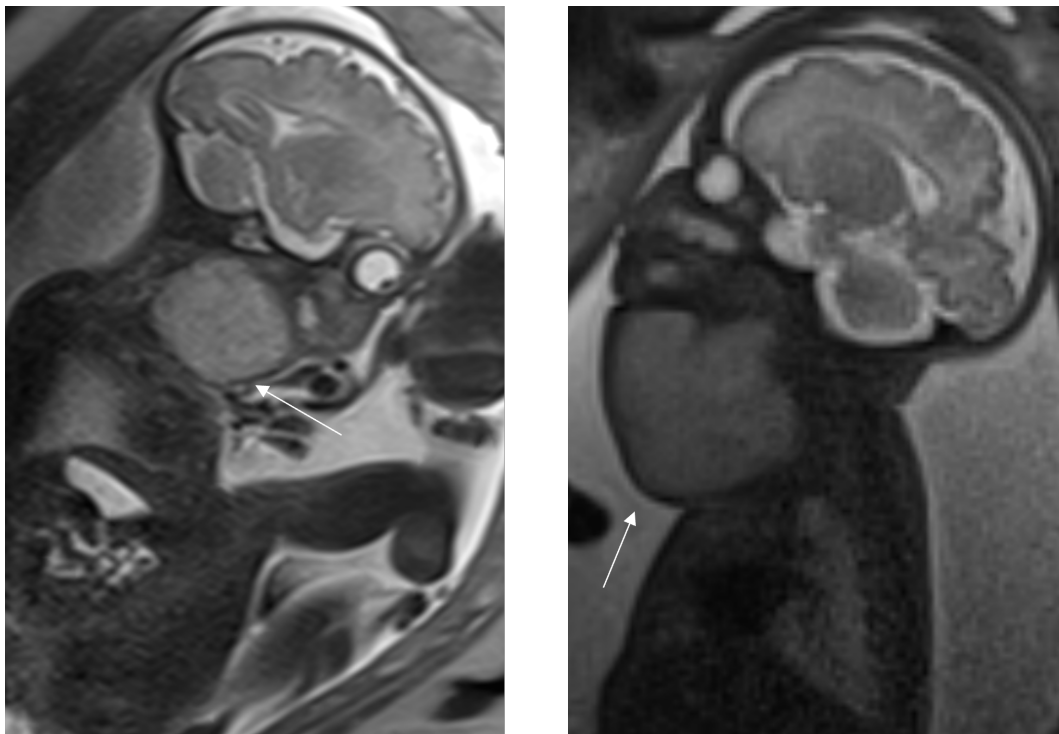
Fetal MRI images of rhabdomyosarcoma
